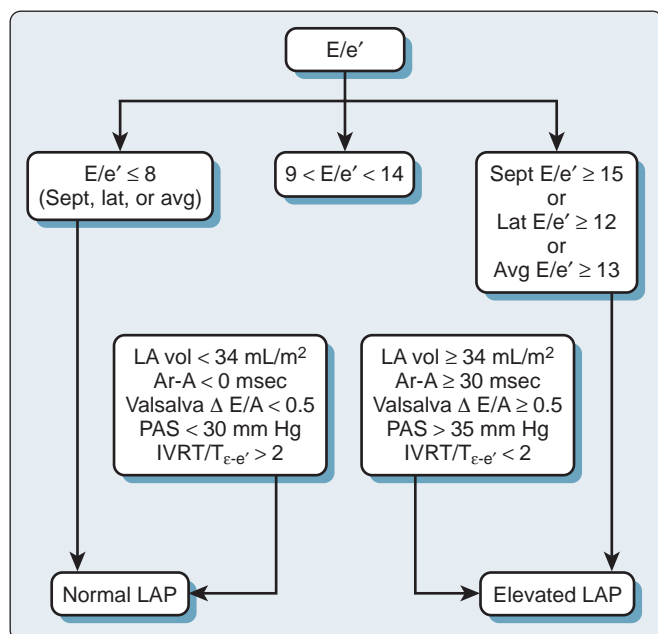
Evaluation of left atrial pressure (LAP) in normal ejection fraction. A, Late diastolic transmitral velocity; Ar-A, difference between pulmonary venous atrial reversal duration and transmitral A-wave duration; Avg, average; DT, E-wave deceleration time; E, early diastolic transmitral velocity; e', early diastolic tissue Doppler velocity; IVRT, isovolumic relaxation time; LA, left atrial; Lat, lateral; PAS, pulmonary artery systolic pressure; Sept, septal.
